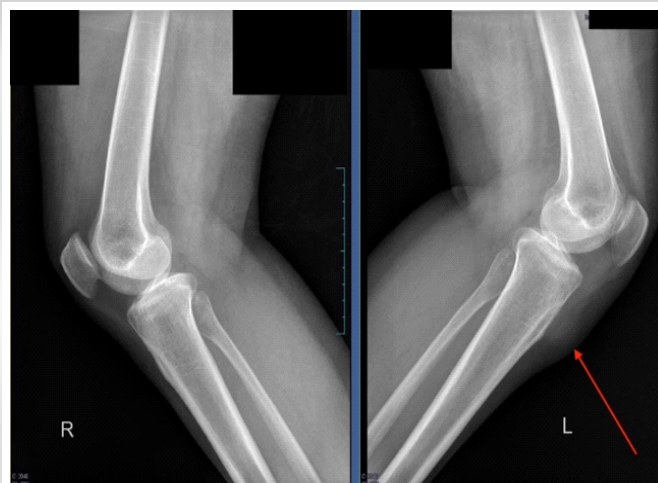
Pre-operative X-rays of the bilateral knee in lateral view. X-rays of the bilateral knees in lateral view showing soft tissue shadow (red arrow) on the left side.
